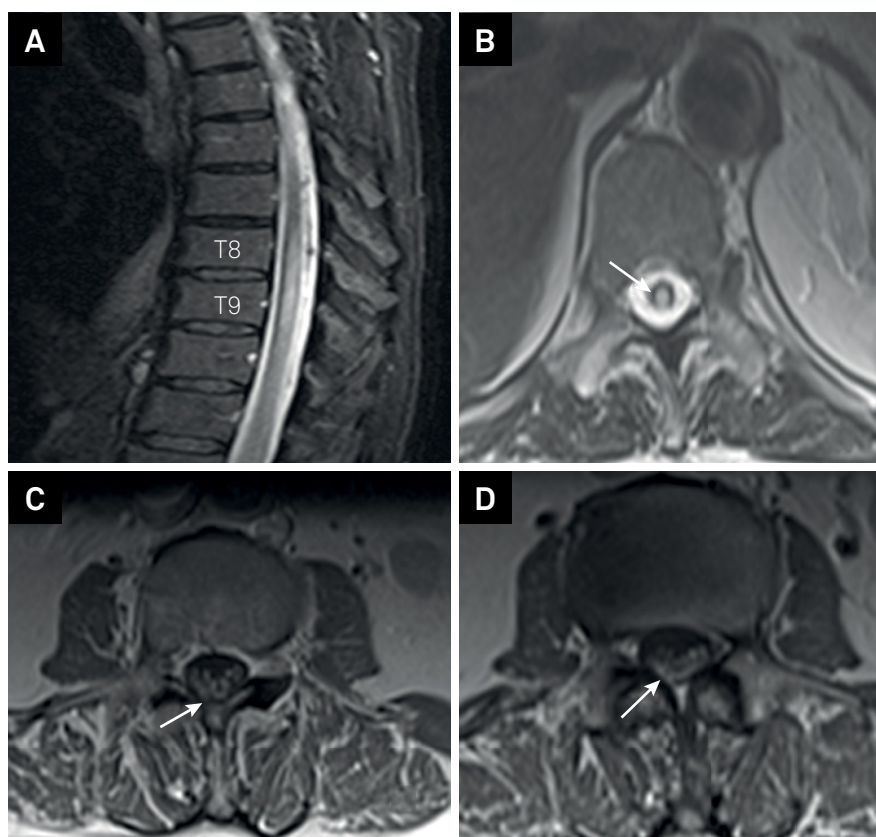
Sagittal (A) and axial (B) T2-weighted MRI show marked hydromyelia at T8-T9 level. Axial lumbar T1-weighted with gadolinium MRIs (C,D) show diffuse enhancement of cauda equina's nerve roots (arrows).
